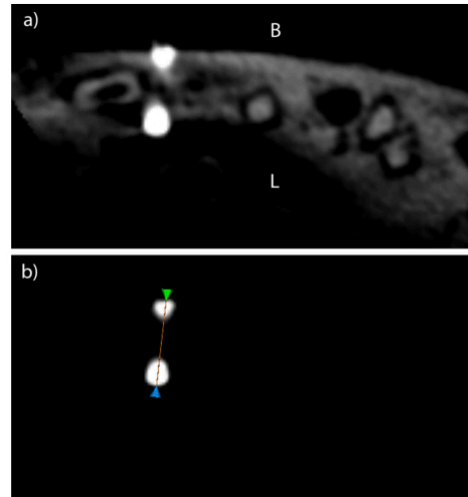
CBCT images from MicroView displaying gutta percha points at 3 mm from the alveolar crest at (a) commonly viewed settings; the buccal surface of the mandible is marked as B, and the lingual surface is marked as L. The same image (b) after using the window and level function to eliminate grey values below a threshold in order to display the gutta percha points only and using the measurement tool to measure the distance.
